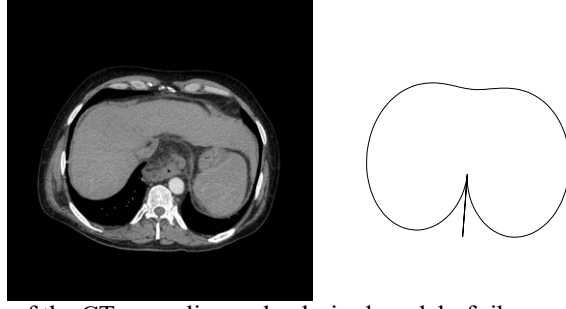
Example of the CT scan slice and a desired model of ribs-contour in this CT slice.
